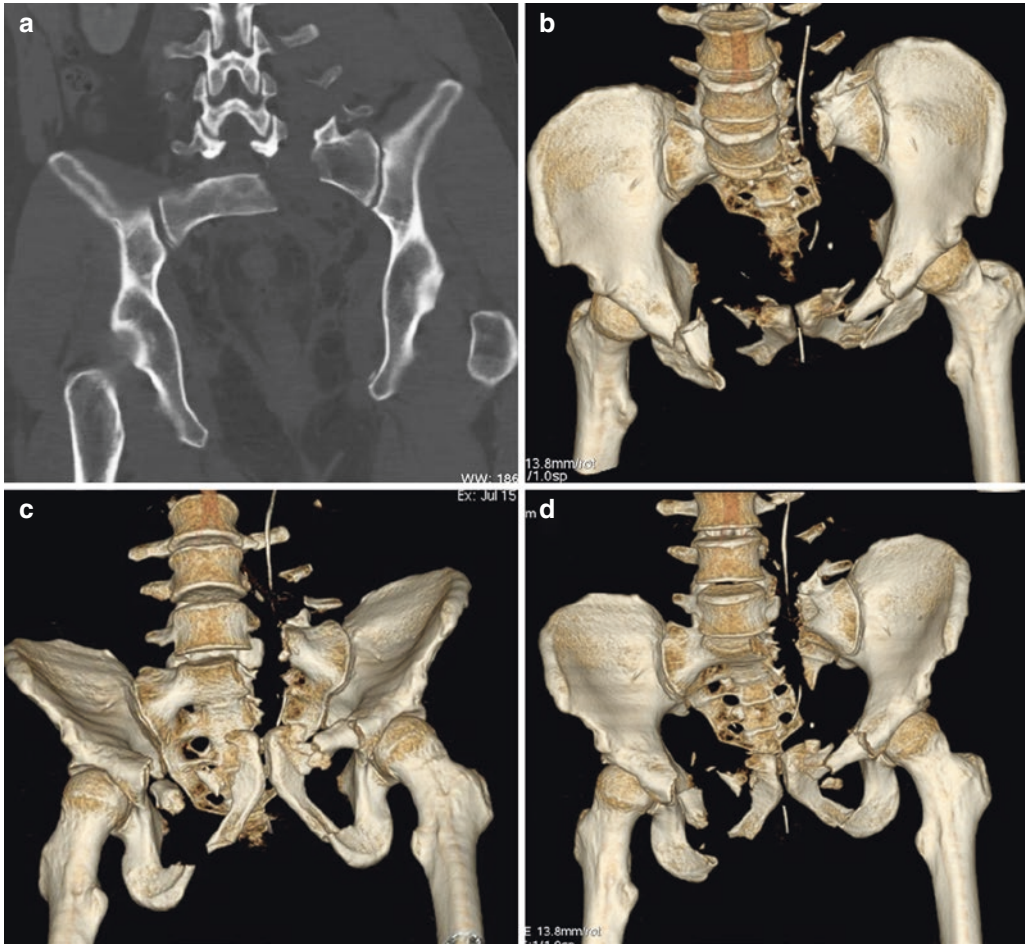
(a–d) “Vertical shear” (VS) fracture. (a) CT MPR coronal view; CT 3D (VR) reconstruction AP view (b, d) and posterior view (c) show bilateral fractures of pubic rami (horizontal force component), sacroiliac fractures, and dislocation with consequent cranial dislocation
